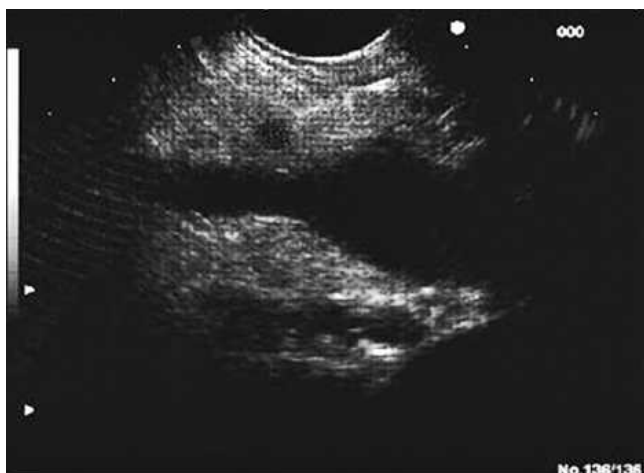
Endoscopic ultrasound-guided fine-needle aspiration of the pancreatic lesion showed a neuroendocrine islet tumor.
